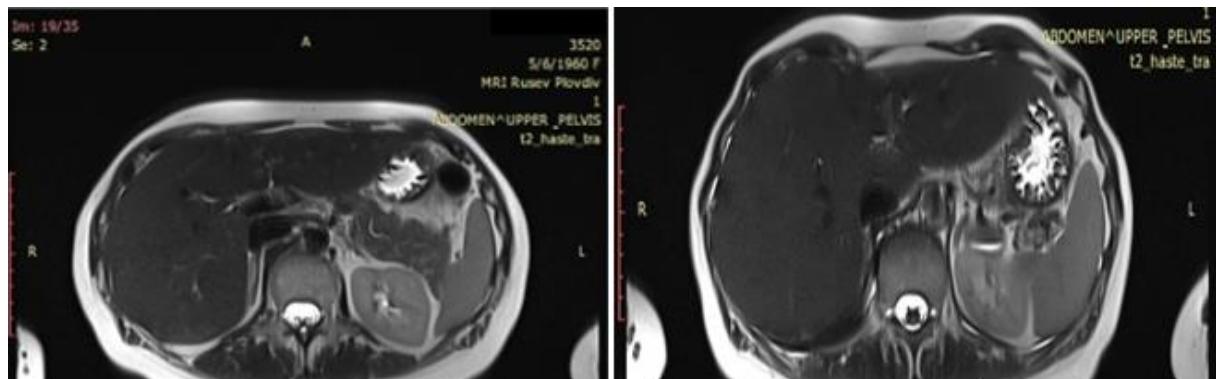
Abdominal MRI: Enlarged pancreatic body and tail, enlargement of the pancreatic duct. A hyperintense lesion in T2 is seen under the pancreatic tail.
